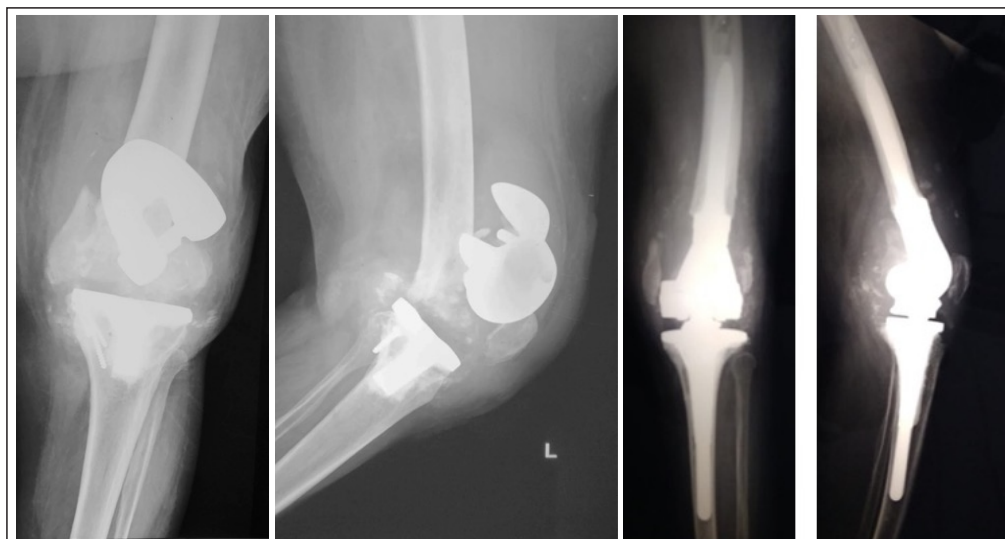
a-Pre-op AP Xray-Rorabeck&Taylor Type 3 Supracondylar femur fracture, b-Pre-op Lateral Xray-Rorabeck&Taylor Type 3 Supracondylar femur fracture, c-Post-op Xray-Rorabeck&Taylor Type 3 Supracondylar femur fracture
